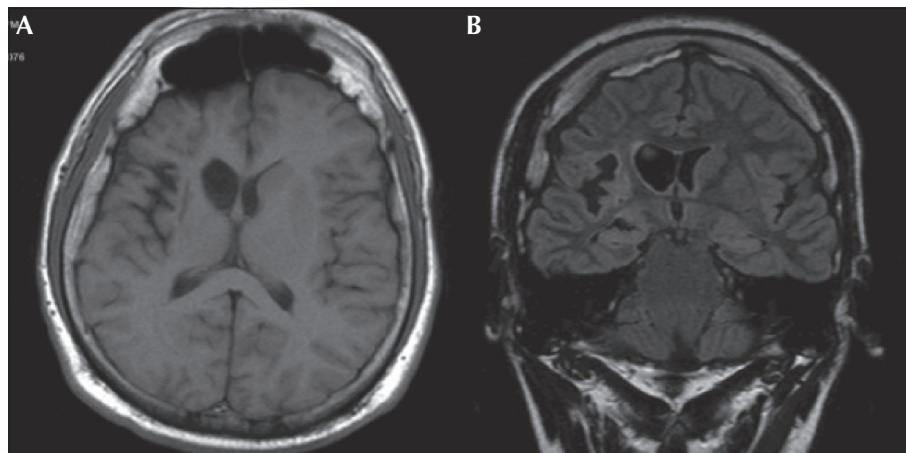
Axial T1-weighted (A) and coronal FLAIR (B) MR images of Patient 2, demonstrating typical atrophy on the right hemisphere.
